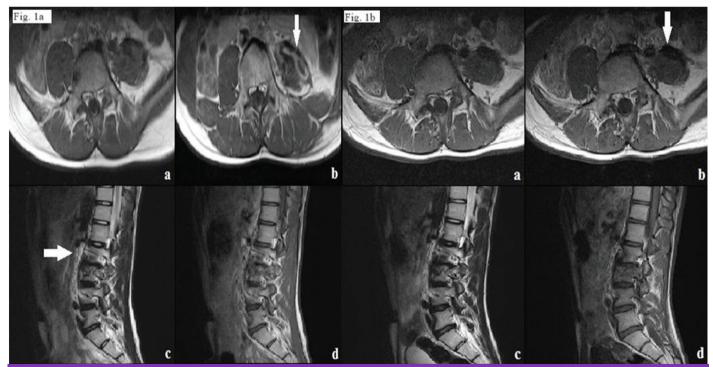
Abdominal MRI reveals a multiloculated, septated cystic lesion (arrow) originating from the paravertebral region, extending into the medullary cavity of lumbar vertebrae and displacing the left kidney anterosuperiorly. (a) T1-weighted axial MRI (b) T1-weighted axial MRI with contrast; Figure 1b. There are several residual, inactive foci (arrow) in the paravertebral area, at the site of the previous hydatid cyst as revealed by the control MRI at month 6 after treatment. The bone involvement was stabil (a) T1-weighted axial MRI image (b) T1-weighted axial MRI with contrast (c) T2-weighted sagittal MRI (d) T1-weighted sagittal MRI with contrast
